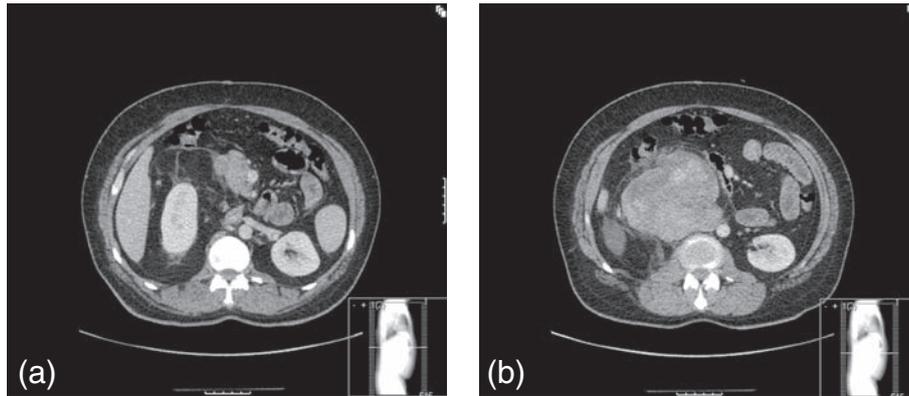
Two computed tomography scans of a retroperitoneal liposarcoma. (a) Abnormal fat surrounding the right kidney. (b) Dedifferentiated component compressing the inferior vena cava and with colon overlying it.
